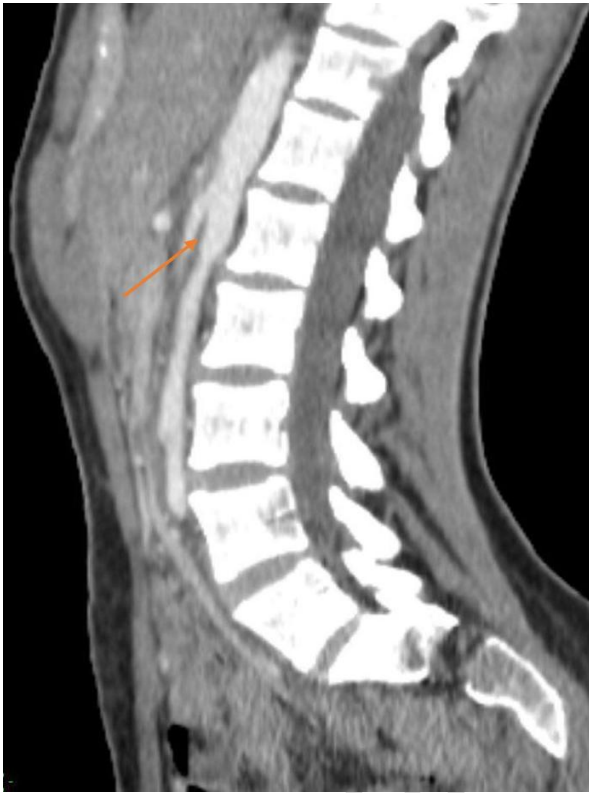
Sagittal section of abdominal CT scan with PDC injection showing pinching of the superior mesenteric aorta-arterial angle.
